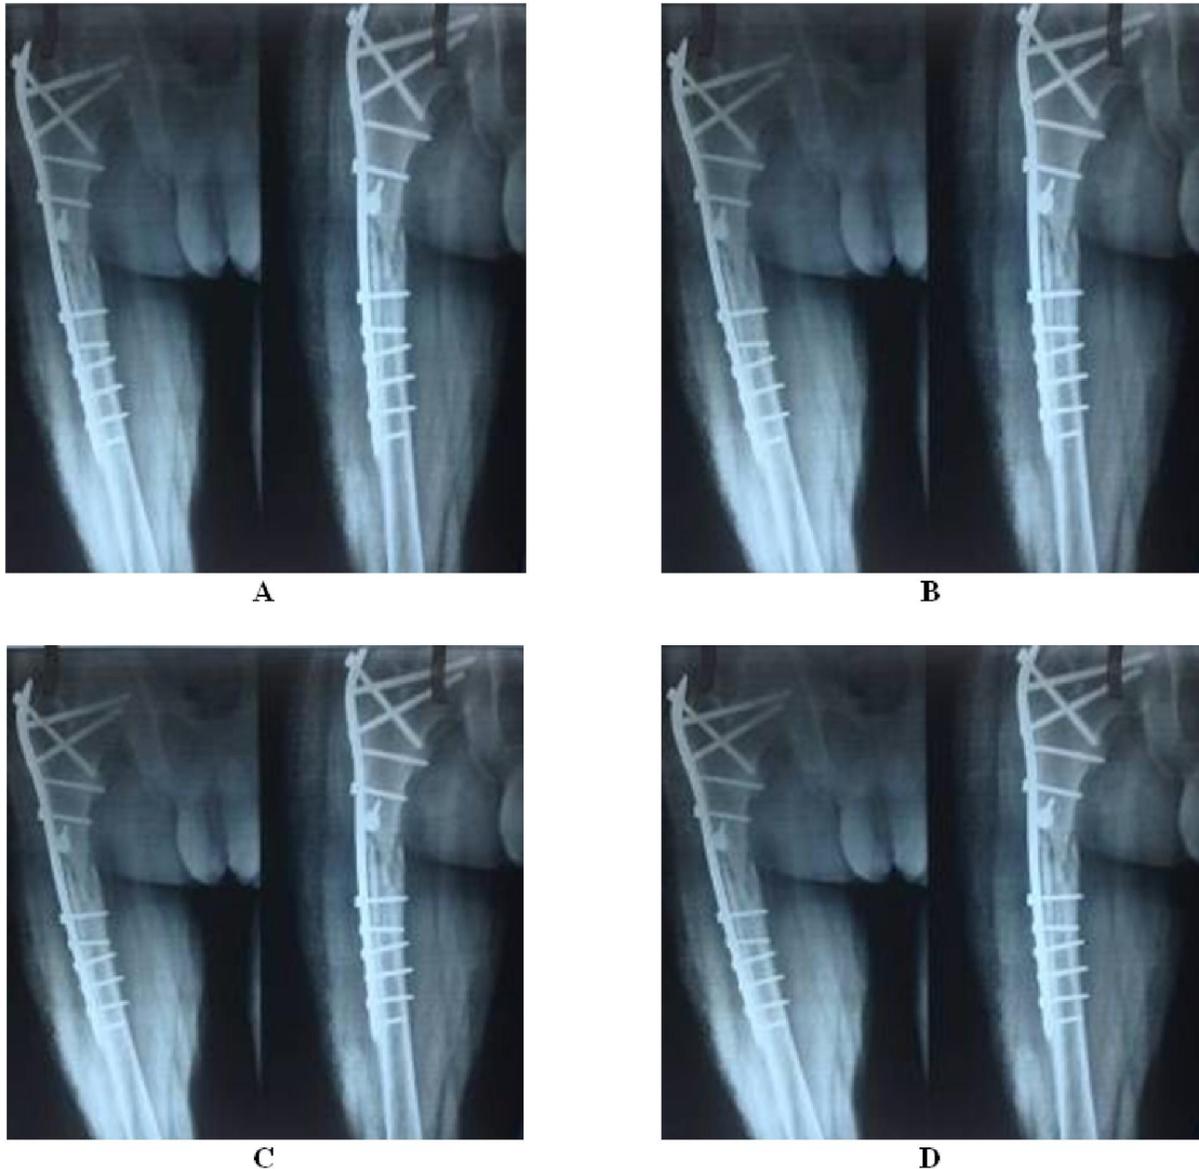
A 26-year-old man, 15.0 months after road traffic accident and closed subtrochantric fracture right femur treated immediately by proximal femoral plate and bicortical bone grafting. At presentation in our facility, the Pre-operative anteroposterior radiograph (A), three weeks after first bone marrow injection (B) and radiograph after third time of bone marrow injections (C). After the fourth time percutaneous autologous bone marrow injection, the patient's radiograph (D) showed nonunion. At final follow-up 15 months after marrow injection, the patient reported (38/50 according to Calori et al. (1) nonunion scoring system).
